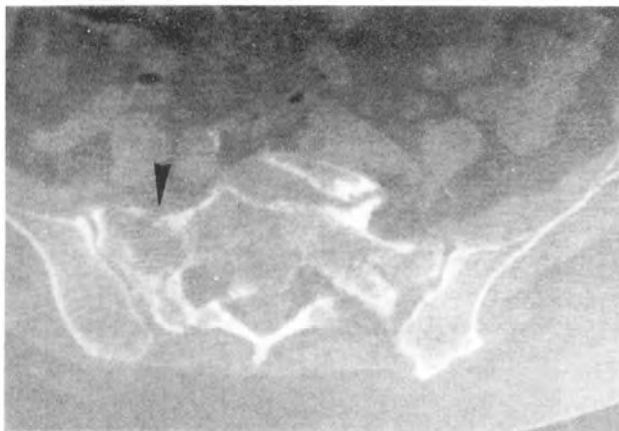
Computed tomography scan of the pelvis shows osteoblastic and radiation necrosis changes of the sacrum and ilia (arrow-heads) as well as the vertical fracture line that parallels the sacroiliac joint on the right side (open arrow) and a suggestion of one on the left that is not as well delineated.
